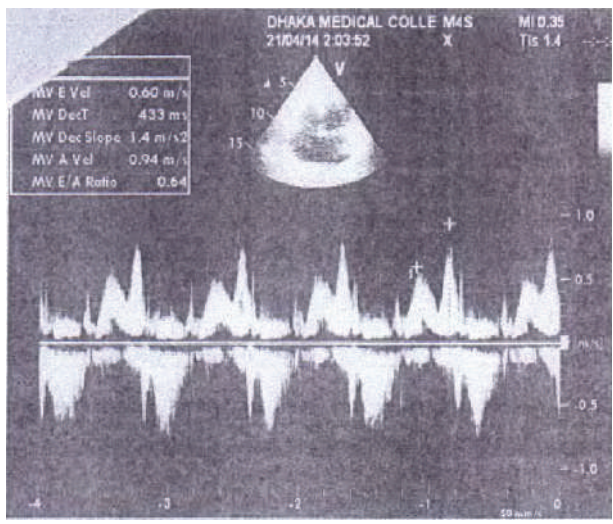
5 Standard Doppler mitral inflow pattern in a preeclamptic woman where peak MV E/A ratio is 0.64 and deceleration time is 433 ms.
